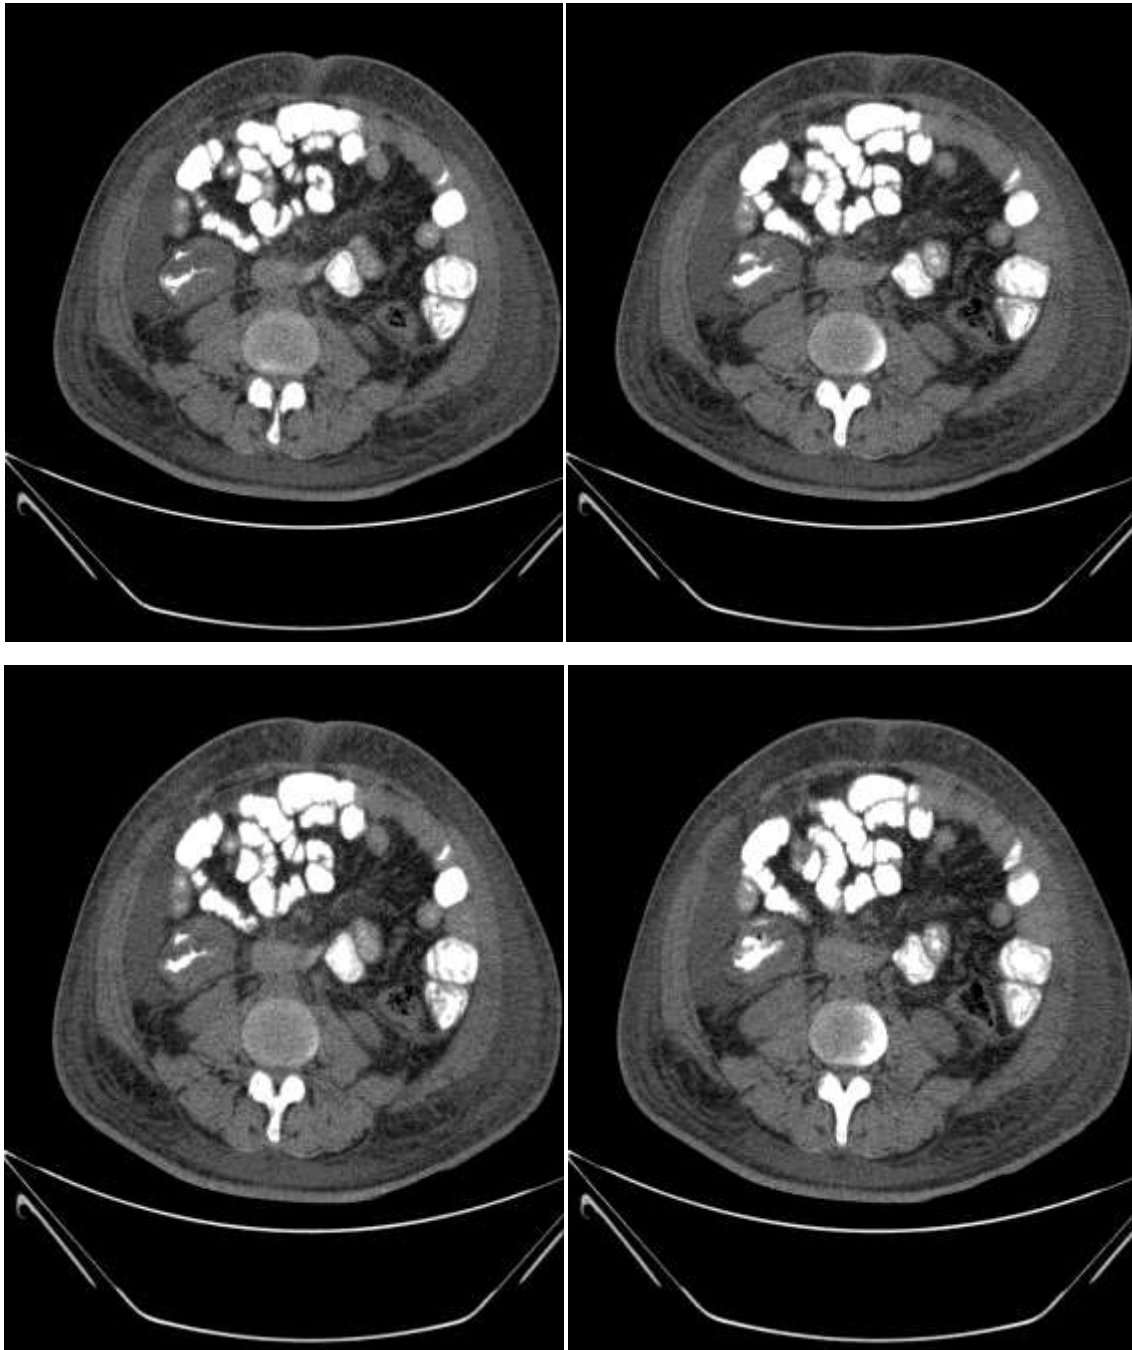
Abdomen and pelvic CT scan (transverse section).
